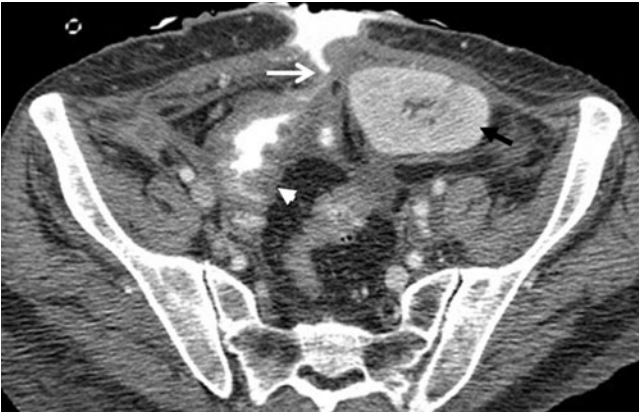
Axial CT with intravenous and enteral contrast in a patient post-SPK depict thickening of pelvic small bowel loop (*white arrowhead*) and an enterocutaneous fistula (*white arrow*). Note the transplant kidney sited within the left iliac fossa (*black arrow*).
